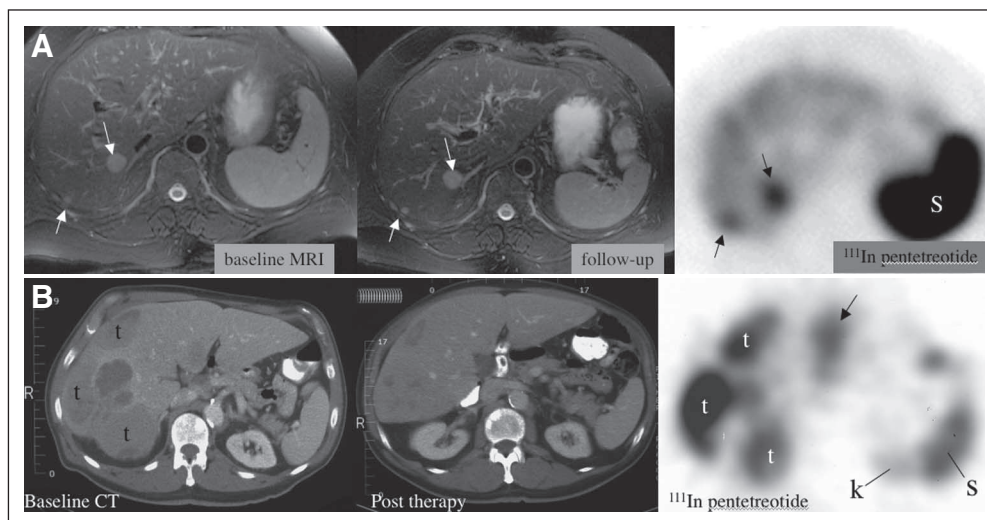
(A) Pretherapy (baseline) and follow-up T2 weighted axial magnetic resonance (MR) images from a patient classified as stable disease who nevertheless demonstrated substantial clinical improvement and is alive more than 5 years after treatment. These images depict two of the 11 hepatic metastases seen on the complete MR imaging (MRI) exam. The axial single-photon emission computed tomography ^{111}In -pentetreotide image on the right demonstrates significant concentration of the radiolabeled octreotide in the two lesions seen on MRI (arrows). (B) Pre- and post-therapy axial computed tomography (CT) images from a patient classified with partial response at the level of the upper pole of the left kidney and demonstrate substantial reduction in the size of multiple large hepatic metastases (t). Black arrow indicates uptake in a hepatic metastasis that is not seen on CT (S indicates spleen and K indicates upper pole of the left kidney on the pentetreotide image). This patient displayed dramatic clinical improvement as well.
